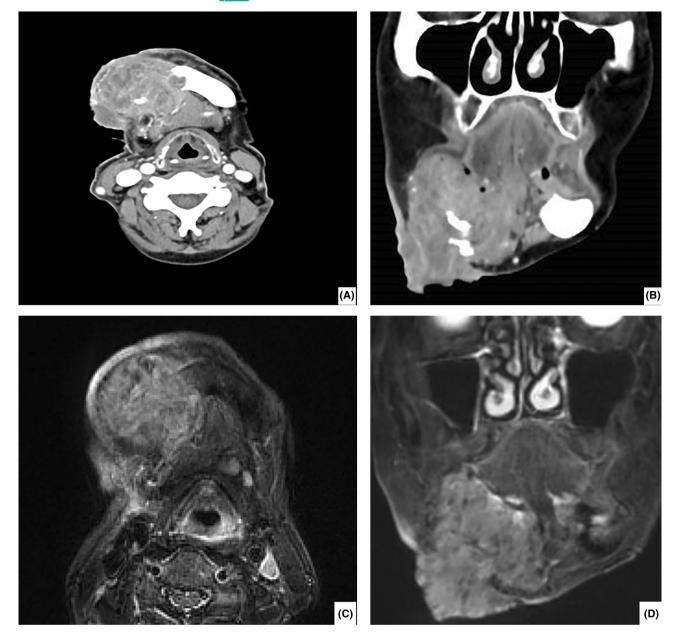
CT and MRI showing a homogeneous mass on the right side of the mandible (A) contrast-enhanced axial CT image (B) contrast enhanced coronal CT image (C) axial short inversion time inversion recovery (STIR) image (D) coronal STIR image.
